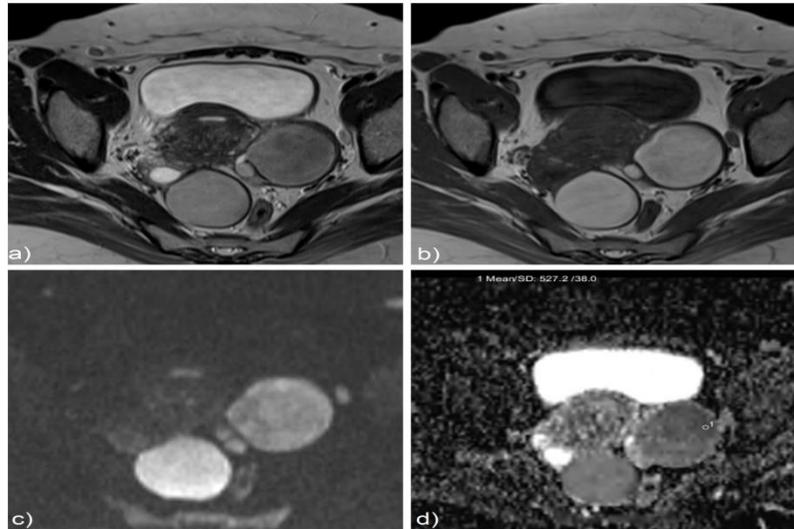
MRI pelvis showing bilateral ovarian endometriotic cysts; a) Axial T2W image showing two well defined, hyperintense cystic lesions in both ovaries showing T2 shading sign; b) Axial T1WI these lesions are appearing hyperintense; c) & d) b value and ADC images of diffusion weighted imaging, showing diffusion restriction, with corresponding low ADC value of $0.52 \times 10^{-3} \text{mm}^2/\text{s}$.
